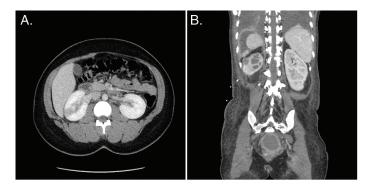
(A) On CT lobar nephronia in right kidney is characterized by intraparenchymal lesion similar in density to normal tissue that is poorly perfused on contrast enhanced imaging, with no rim enhancement. (B) Renal abscess in right kidney is characterized by defined fluid collection, often intraparenchymal.
